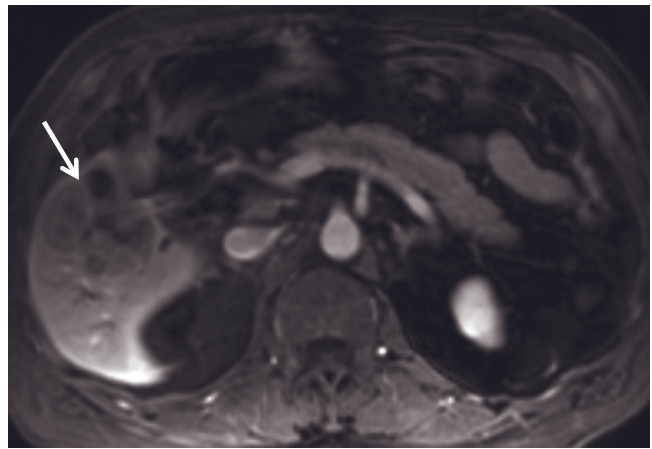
Peripheral cholangiocarcinoma. T2-weighted single-shot echo-train spin-echo (a), T1-weighted GE (b), immediate postgadolinium GE (c), and 2-min postgadolinium fat-suppressed GE (d) images. A large tumor with intrahepatic metastases is observed in the right lobe of the liver. The signal is moderately hyperintense on the T2-weighted image (a) and hypointense on the T1-weighted image (b). On the immediate postgadolinium image (c), the tumors are hypoenhancing and demonstrate mild perilesional enhancement. Progressive heterogeneous enhancement of the tumors is observed on the 2-min postgadolinium image (d).
